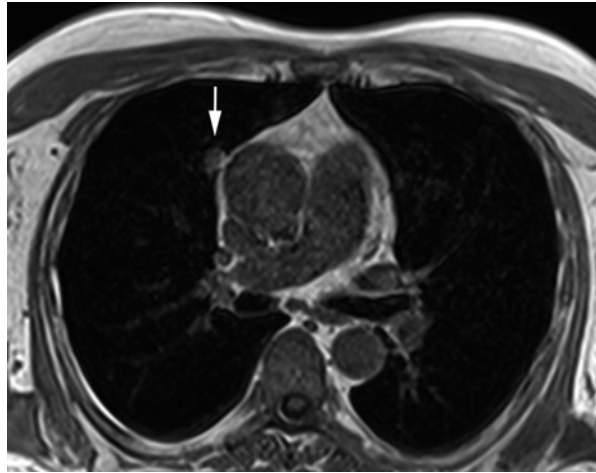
Incidental solitary pulmonary nodule with follow-up MRI in a 49-year-old male subject. T1w screening image shows a 9-mm nodule in the right upper lobe (a). No lesion is detectable on follow-up MRI performed 3 months later (b)
